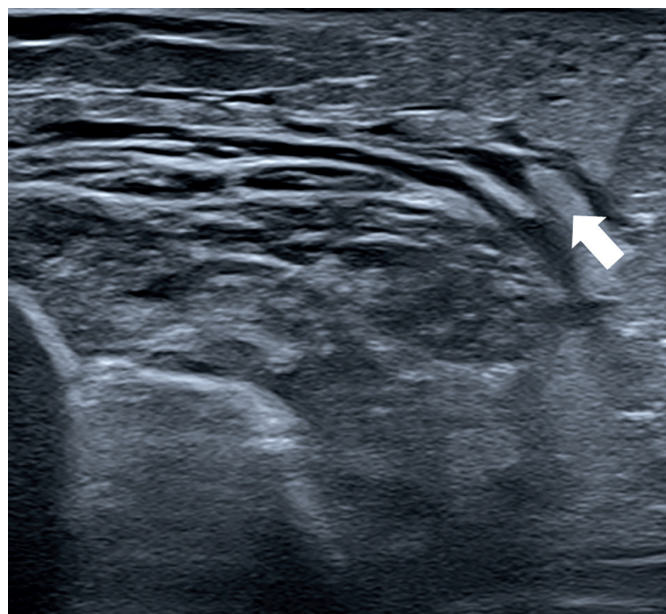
Ultrasonography: Oedema and infiltration of left forearm.
